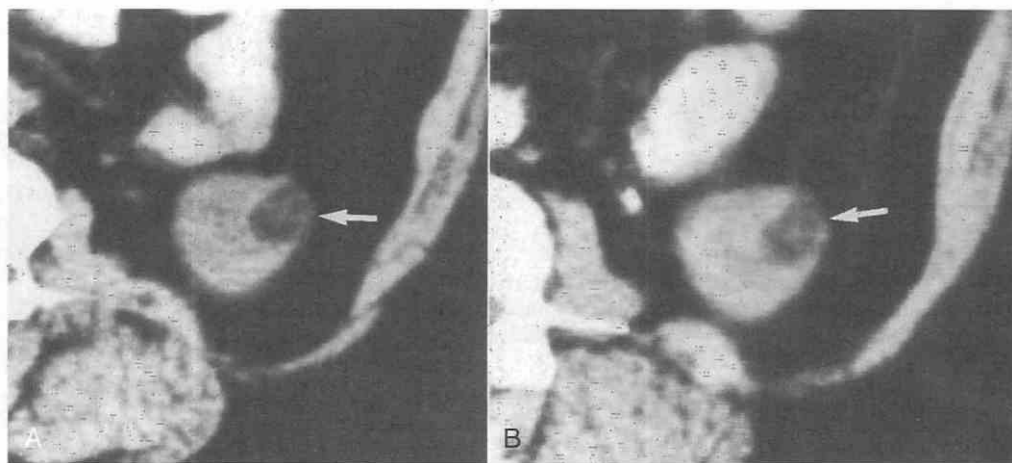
Small renal angiomyolipoma. *A*, Unenhanced CT scan shows a low-density mass (arrow) in the lower pole of the left kidney. Attenuation values as low as -42 HU, indicating the presence of fat, were found in the lesion through the use of small regions of interest. *B*, On a contrast-enhanced CT scan, the attenuation values of the lesion (arrow) were in the soft tissue range.
